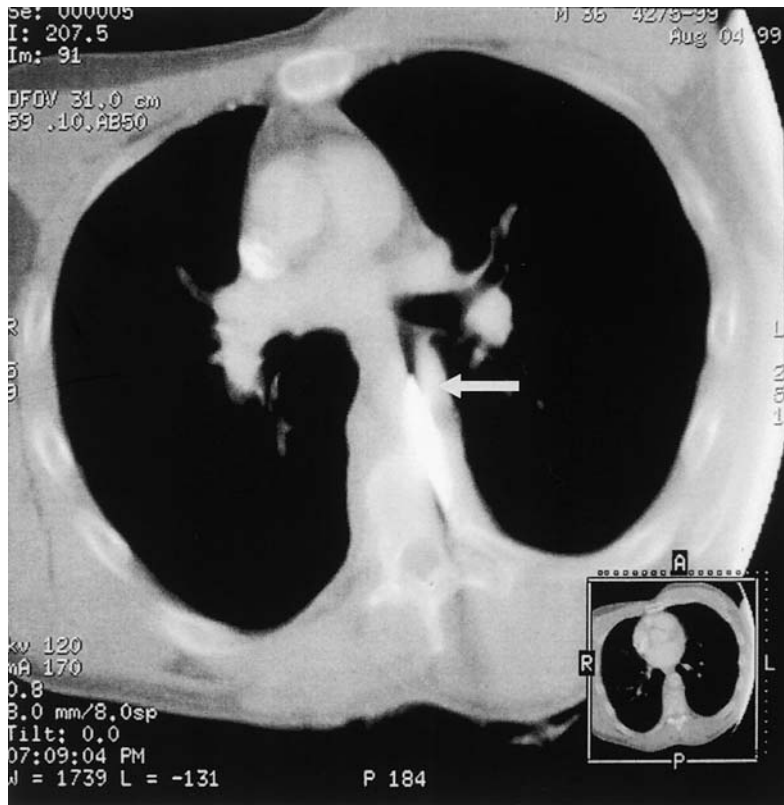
Representative CT section showing the knife piercing the aorta (arrow).
